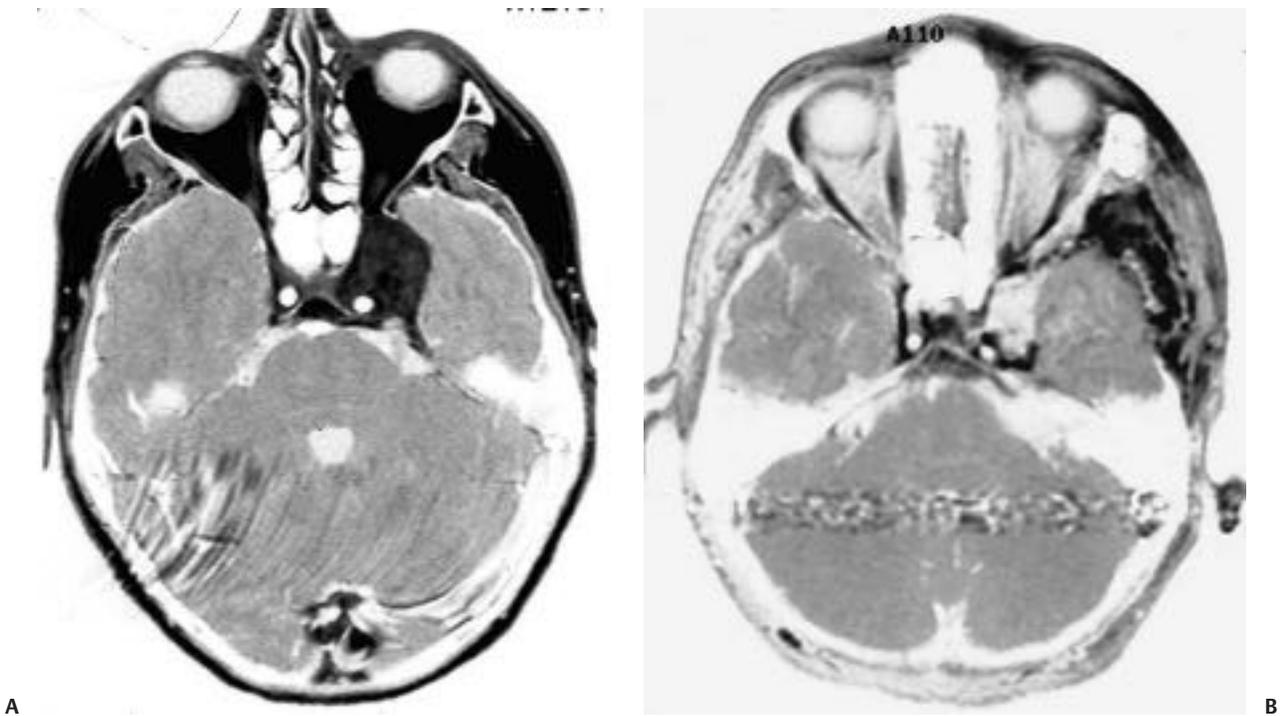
Magnetic resonance imaging of a patient with a left cavernous sinus meningioma. (A) Preoperative image. (B) Image showing complete resection.
